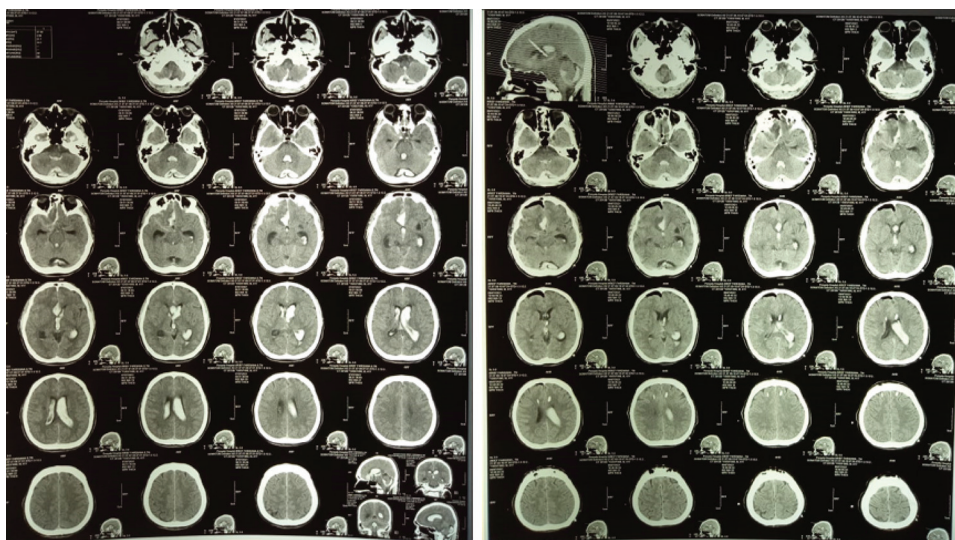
(a, left) Initial CT scan before EVD, (b, right) CT scan day 1 after EVD.
